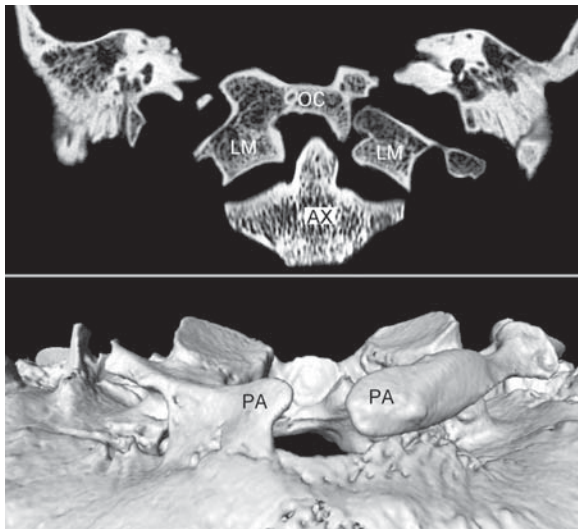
Computed tomography scan of the occipito-atlanto-axial complex in the case of occipitalization, and the 3D reconstruction of the atlas fusion with the cranial base; OC — occipital bone, LM — lateral mass, AX — axis, PA — unfused posterior arch.
